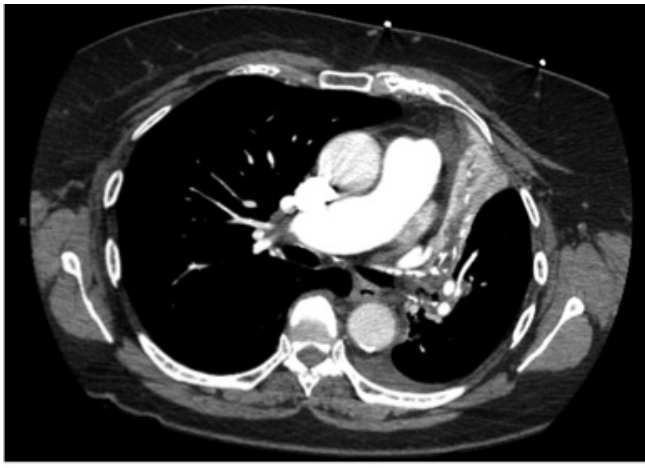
CT of the chest with collapse of left upper lobe and lingula.
